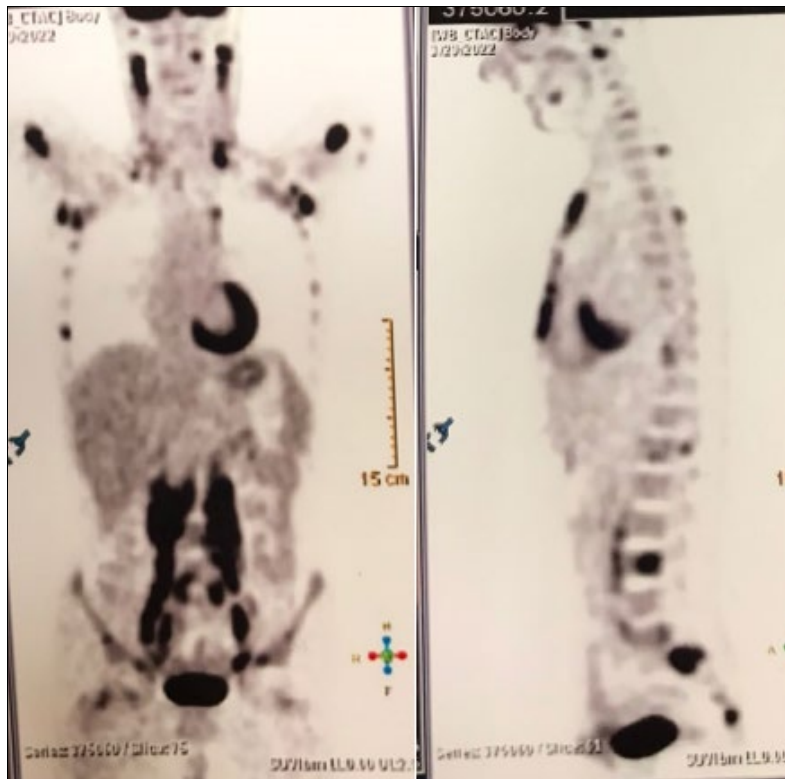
PET scan images showing FDG uptake in bilateral cervical region, axilla, anterior mediastinum, lateral aortic region, bilateral Para aortic, iliac, inguinal region, humerus, sternum, clavicle, C6, D1, D4, D5, D12 and L4, femur and bilateral iliac bones.
